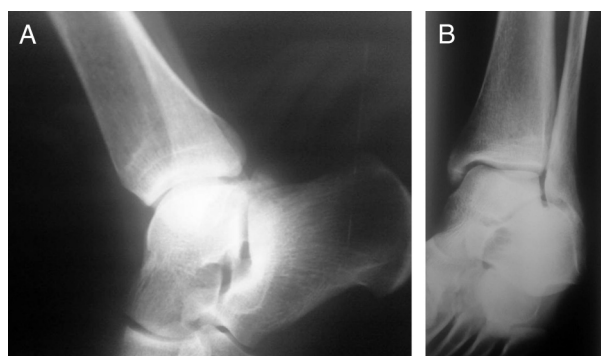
Postreduction radiographs of (A) face and (B) profile showing good alignment of the tibiotalar joint without malleolar fractures.
